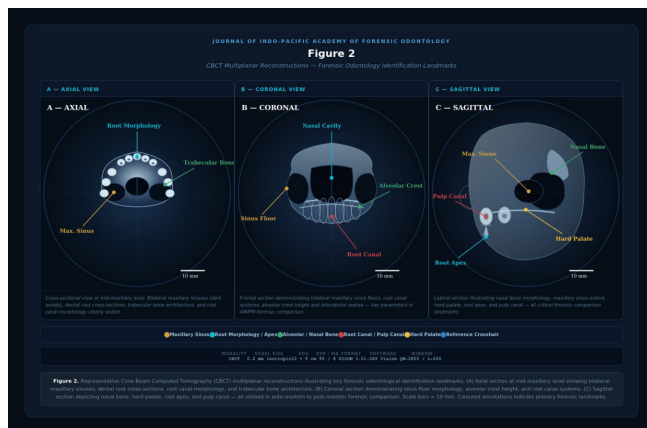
Representative CBCT reconstructions showing dental identification landmarks: (A) Axial, (B) Coronal, and (C) Sagittal views with annotated root morphology and trabecular bone patterns used in forensic comparison.
